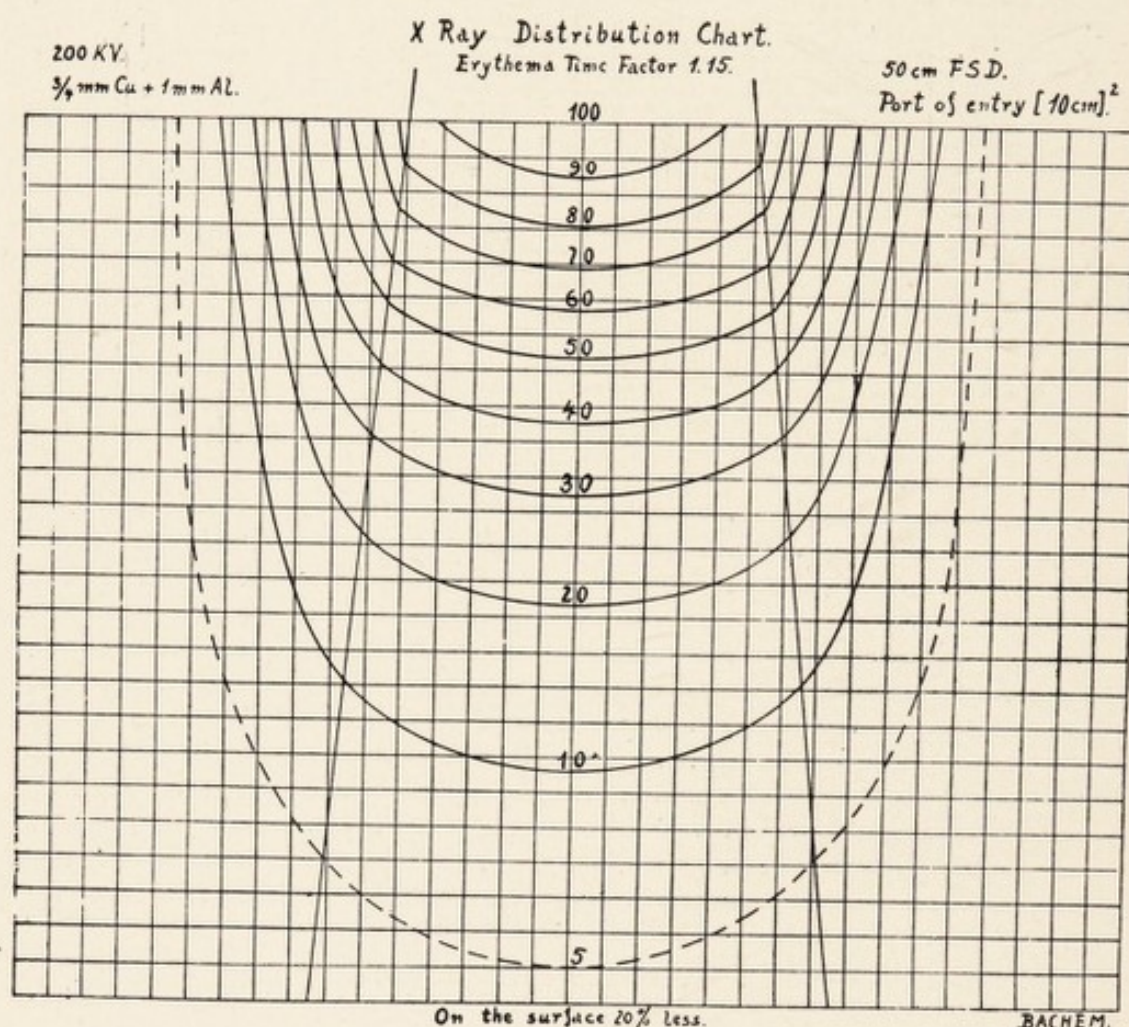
X-RAY EQUAL INTENSITY CURVES IF PORT OF ENTRY IS 10 CM.<sup>2</sup>
